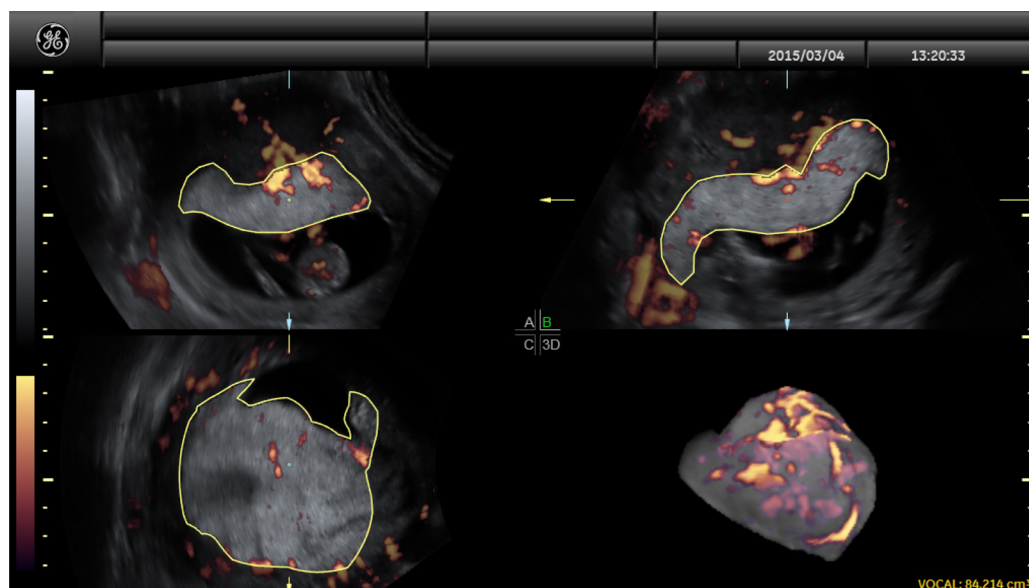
Three-dimensional power Doppler image of the placenta.
